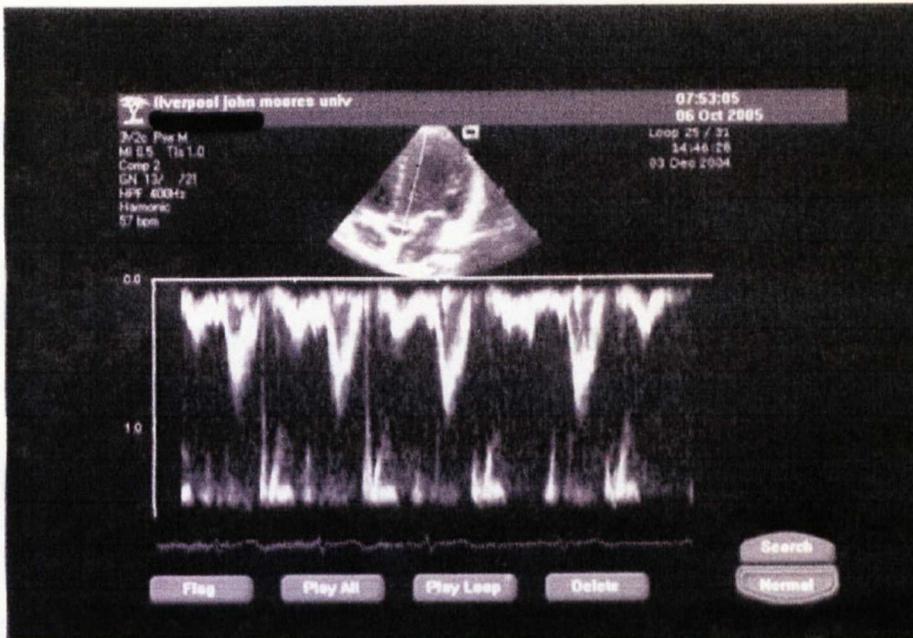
LV Doppler trace of early (E) and atrial (A) filling phases
